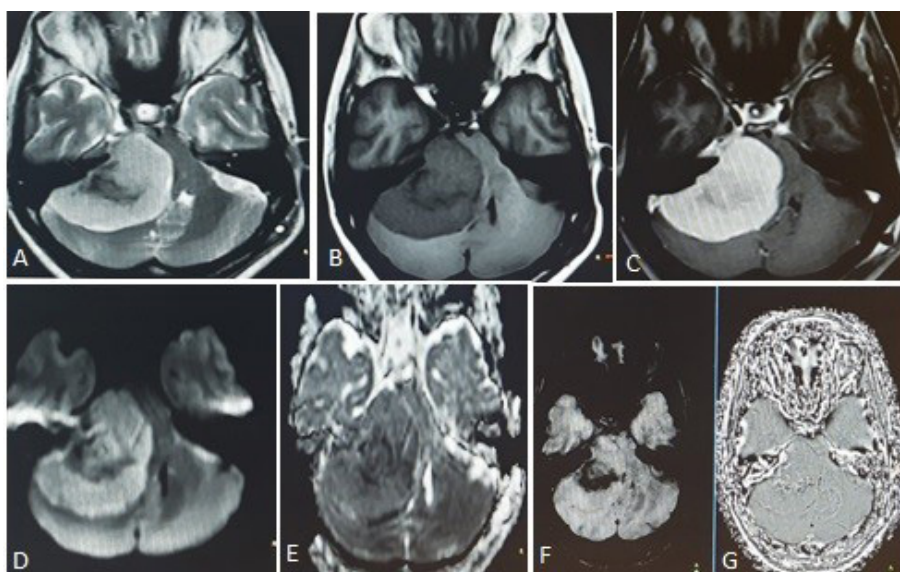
Benign Meningioma. (A) axial T2W, (B) axial T1W, (C) contrast-enhanced T1W, (D) DWI, (E) ADC map, (F) ITSS in SWI and (G) SWI phase images show a benign meningioma in right cerebellopontine angle
